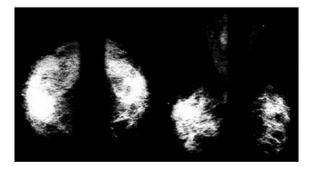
An example of conventional x-ray film mammography. SOURCE: Miraluma Educational CD-ROM, Dupont Radiopharmaceutical Division, The DuPont Merck Pharmaceutical Company.
